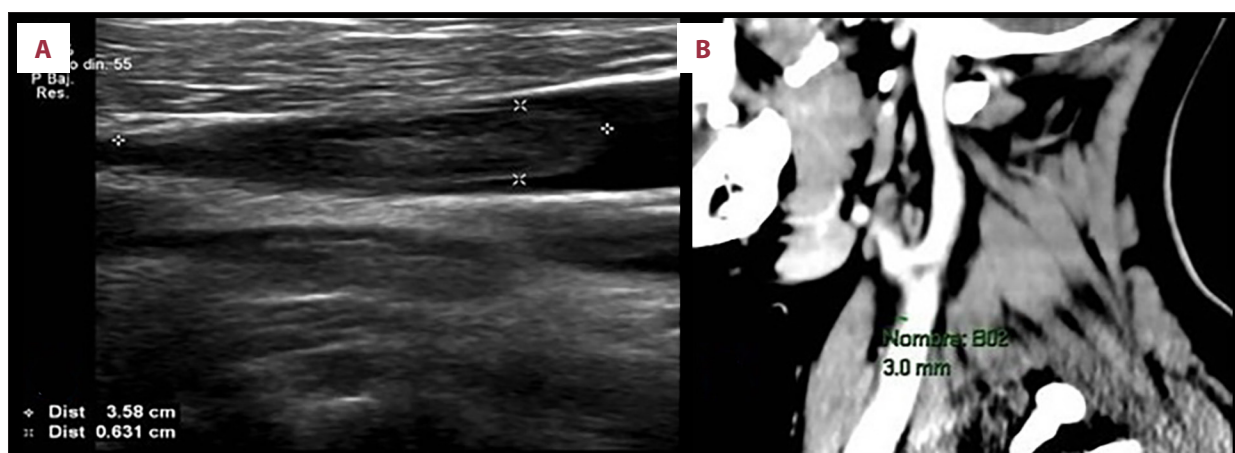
Doppler ultrasound and contrast-enhanced neck computed tomography demonstrate (A) an intraluminal thrombus within the left internal jugular vein on Doppler ultrasound, measuring 3.58 cm in longitudinal diameter, 0.63 cm in anteroposterior diameter, and 0.77 cm in transverse diameter, adherent to the lateral wall and compromising approximately 66% of the vascular lumen; and (B) a thrombus in the left internal jugular vein on contrast-enhanced neck computed tomography, causing approximately 25% luminal stenosis, with absent flow in the left external jugular vein.
